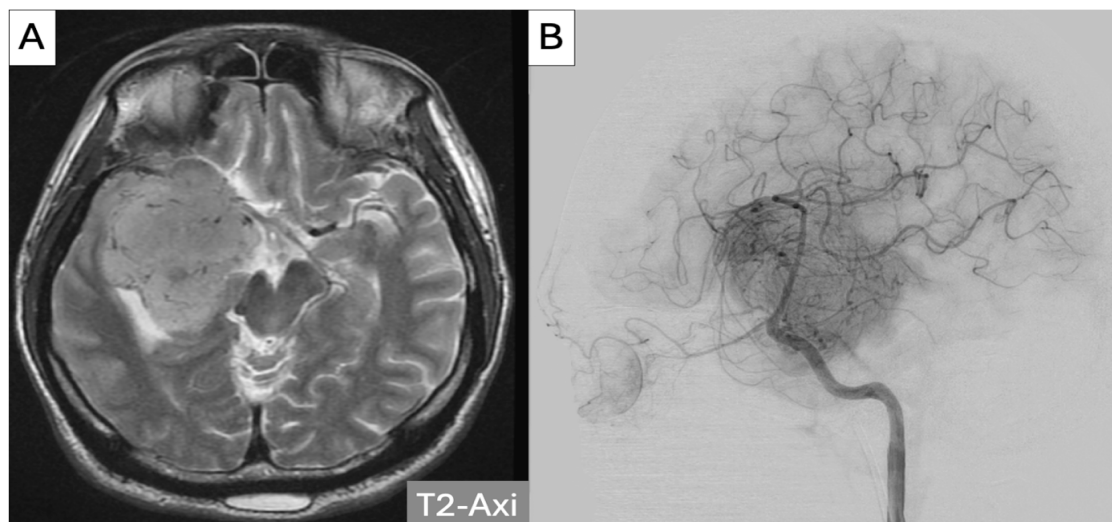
Preoperative brain MRI on the axial plane (A) detected a large tumor in the large sphenoid ridge with angiography vascular proliferation (B) compressing the nearby structure.
